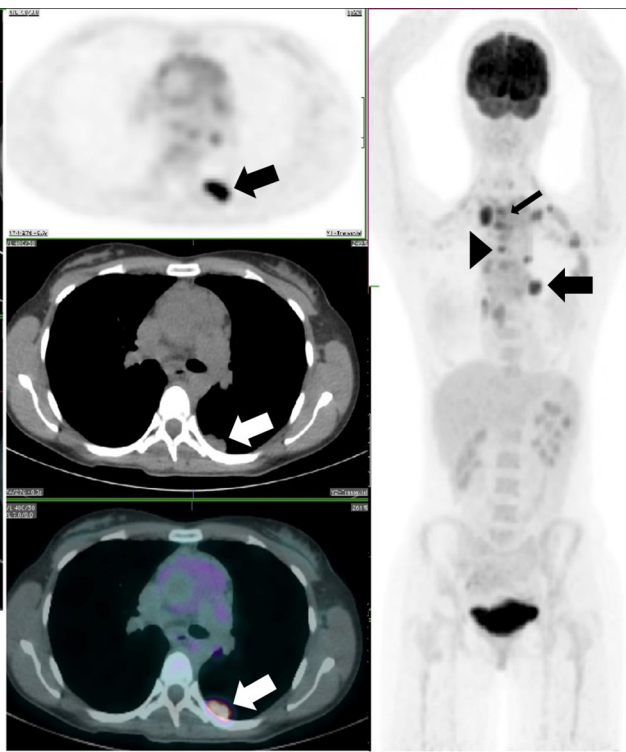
The maximum intensity projection (MIP) image showed intense fludeoxyglucose (^{18}F) (FDG) uptake in multiple nodal stations above the diaphragm (arrowhead) and in the spleen and extranodal involvement (thick arrows) in the left lung (axial positron emission tomography [PET], computed tomography [CT] and fused PET/CT images) and in T1, T2, and T5 vertebral bodies (thin arrow).
